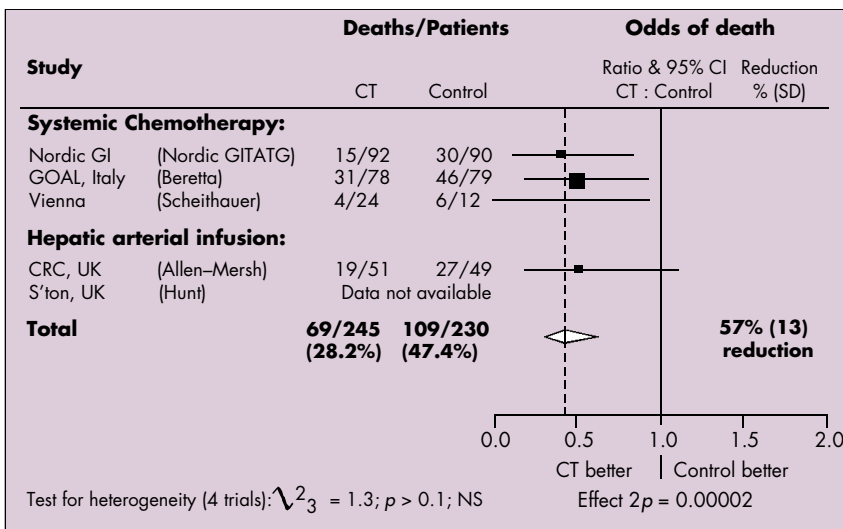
Active chemotherapy (CT) versus symptom palliation only (control) in advanced colorectal cancer; six month survival.
